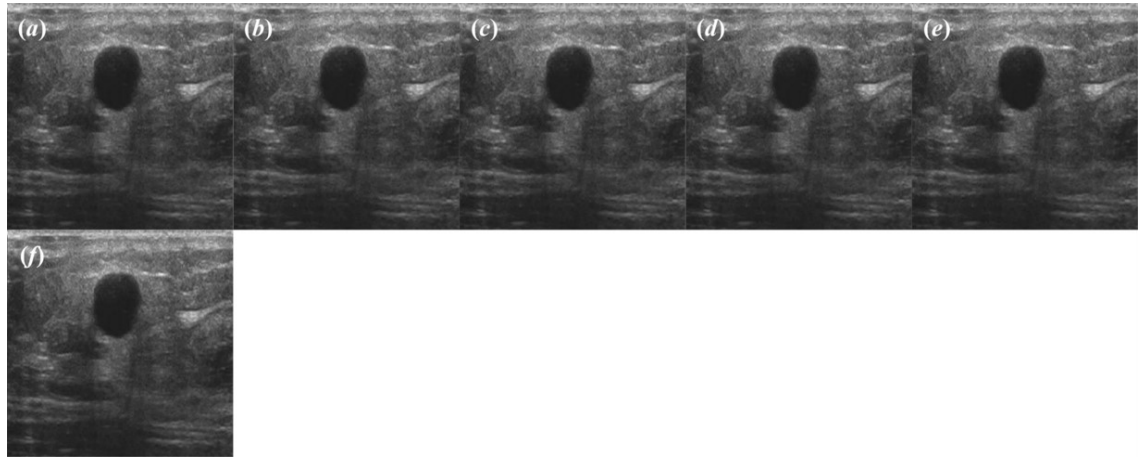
(a) Sample original ultrasound image of benign tumor and (b),-(f) corresponding images despeckled by (b) MPT filter, (c) IOWT filter, (d) BlockShrink filter, (e) BayesShrink filter and (f) NSS filter.
